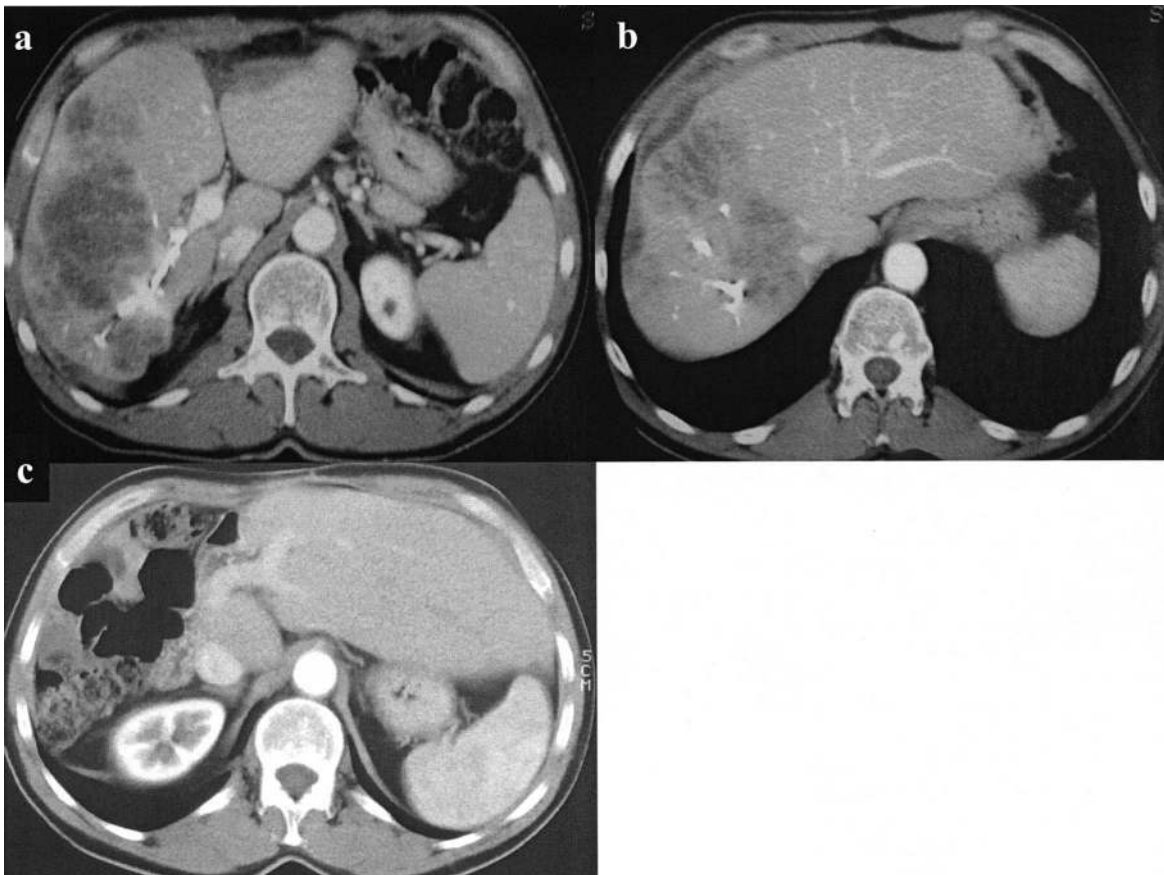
The same case as in Figure 2. CT scan showing nonanatomic resection of segment 3 during the first-stage hepatectomy and coils in the right liver parenchyma as evidence of right portal vein embolization (A), left FRL hypertrophy and patent left hepatic vein after PVE (B), and CT scan 1 year after extended right hepatectomy performed during the second-stage hepatectomy (C).
